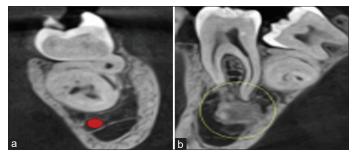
(a) Lingually placed complex odontome associated with 37 and supernumerary tooth; (b) Osteosclerosis in relation to periapical region of 36, with intact lamina dura
